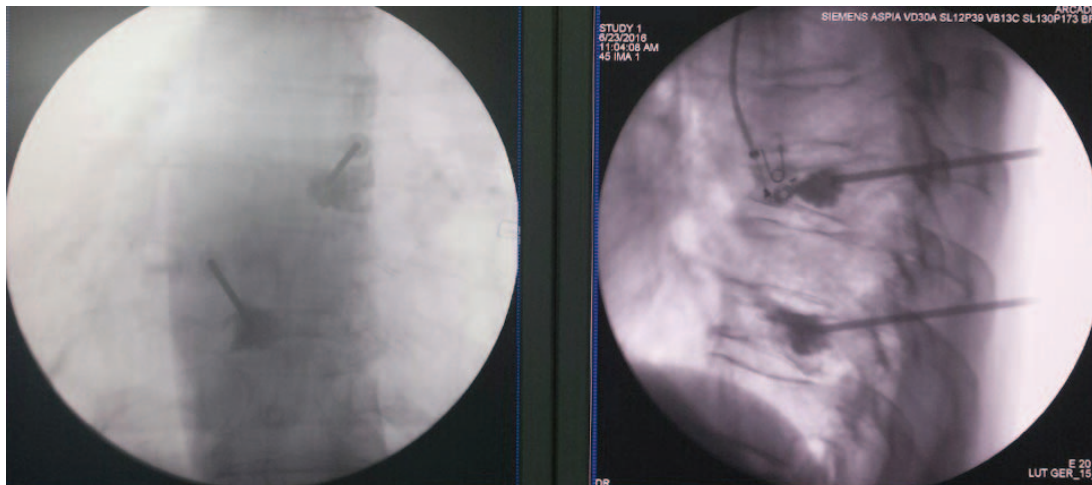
a) Radiographic left-lateral projection: thoracic (Th) vertebrae – de novo fractures of Th8 and Th10 vertebral body before vertebroplasty; b) Radiographic right-lateral projection: primarily fracture of lumbar third (L3) vertebral body.
